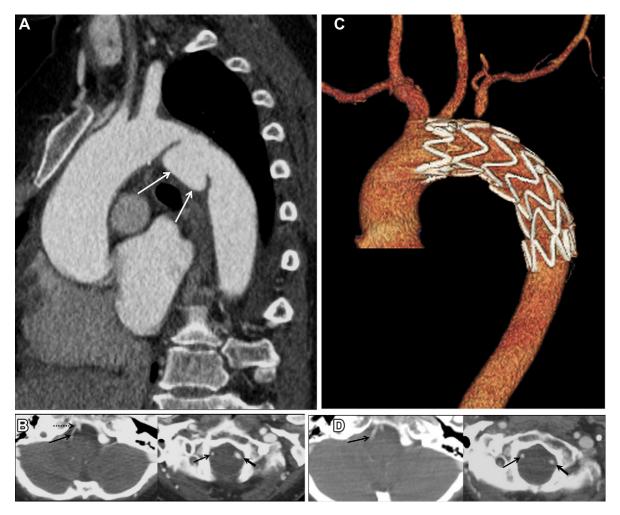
Images are shown for a 73-year-old man with a traumatic aortic pseudoaneurysm. A, A contrast-enhanced computed tomography (CT) scan reveals an aortic pseudoaneurysm (*arrows*) at the proximal descending thoracic aorta. B, A patent vertebrobasilar junction (*dotted arrow*) is demonstrated. The left vertebral artery (VA) (*thick arrow*) is dominant compared with the hypoplastic right VA (*thin arrow*). C, The left subclavian artery (LSCA) is covered, without recanalization, during the stent graft procedure. D, A contrast-enhanced CT scan at the 6-month follow-up reveals the right VA (*thin arrow*) hypertrophy that is nearly the same as the left VA (*thick arrow*).
